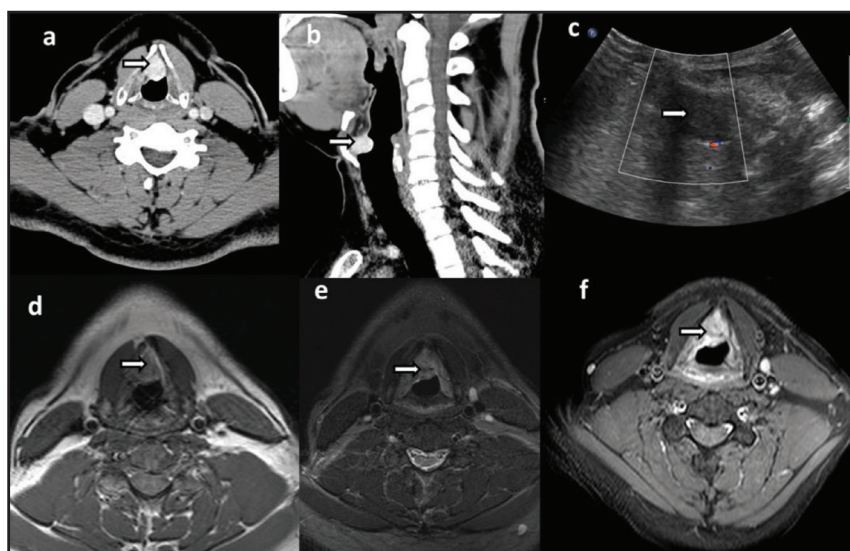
32-year-old male with laryngeal hemangioma, Axial (a) and Sagittal (b) CECT neck demonstrating a well-defined, intensely enhancing lesion in the anterior commissure (long arrows) projecting into the laryngeal lumen. (c) The lesion is hypoechoic on USG. On MRI, the lesion (long arrows) shows mild hyperintensity on T1WI (d), (e) hyperintense signal on T2-STIR, and intense homogeneous post-contrast enhancement (f).
